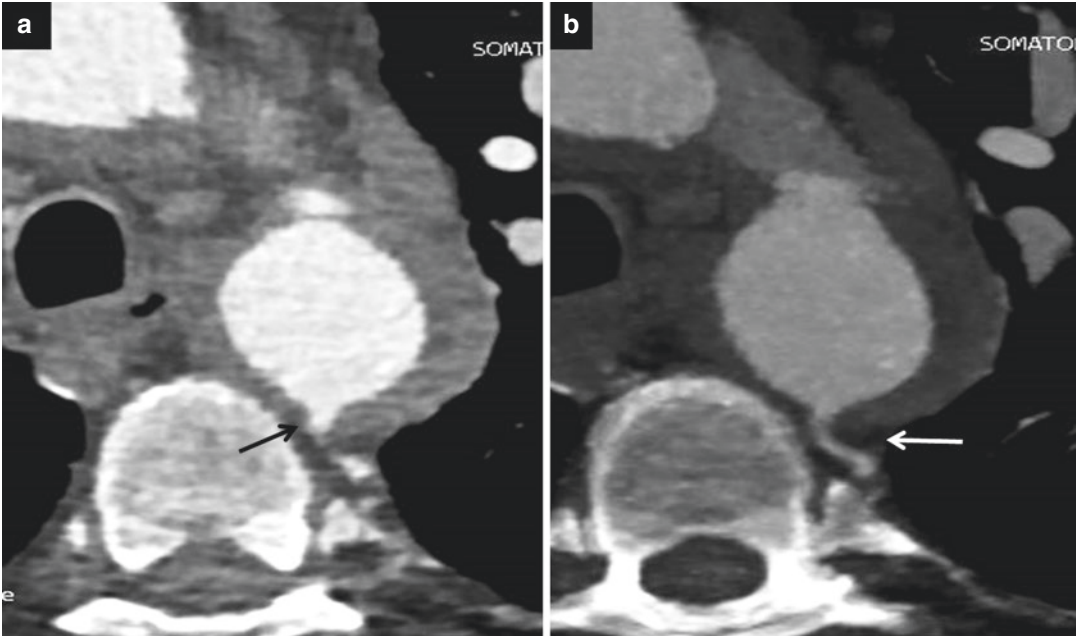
Post-traumatic periaortic hematoma isthmus. (a) Axial CT scan shows ostium intercostal artery mimics small pseudoaneurysm posterior wall (*black arrow*); (b)
